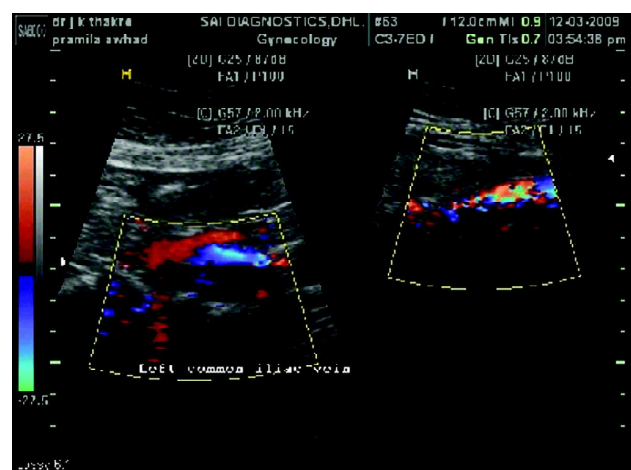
Arterio-venous doppler of left lower limb on admission showing thrombus in left common iliac vein with patchy flow.
